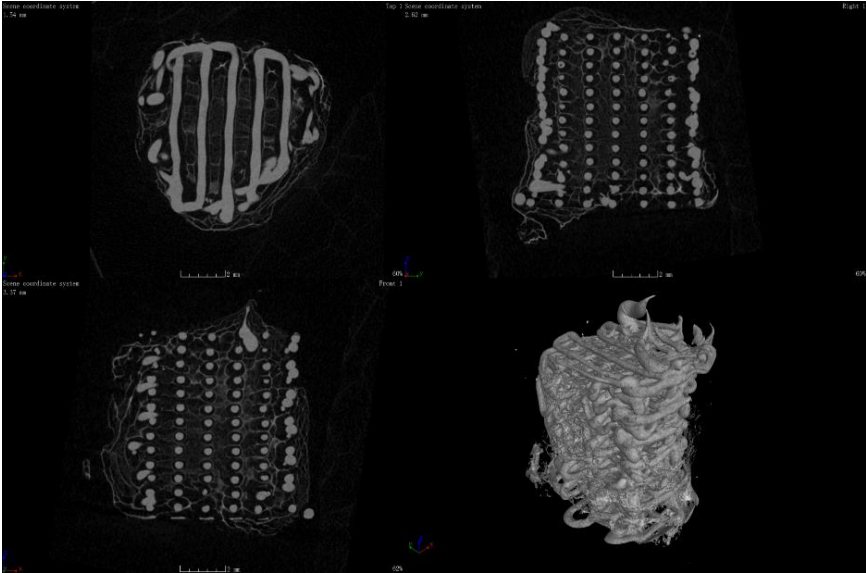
Micro CT scan of PCL scaffold made with extruded PCL in bioplotter and subsequent casting of alginate with nanocellulose.
